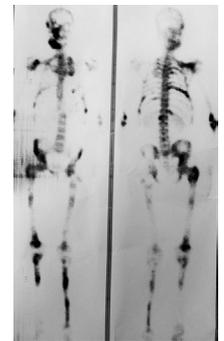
Bone scintigraphy: Multiple diffuse heterogeneous osteoblastic activity
